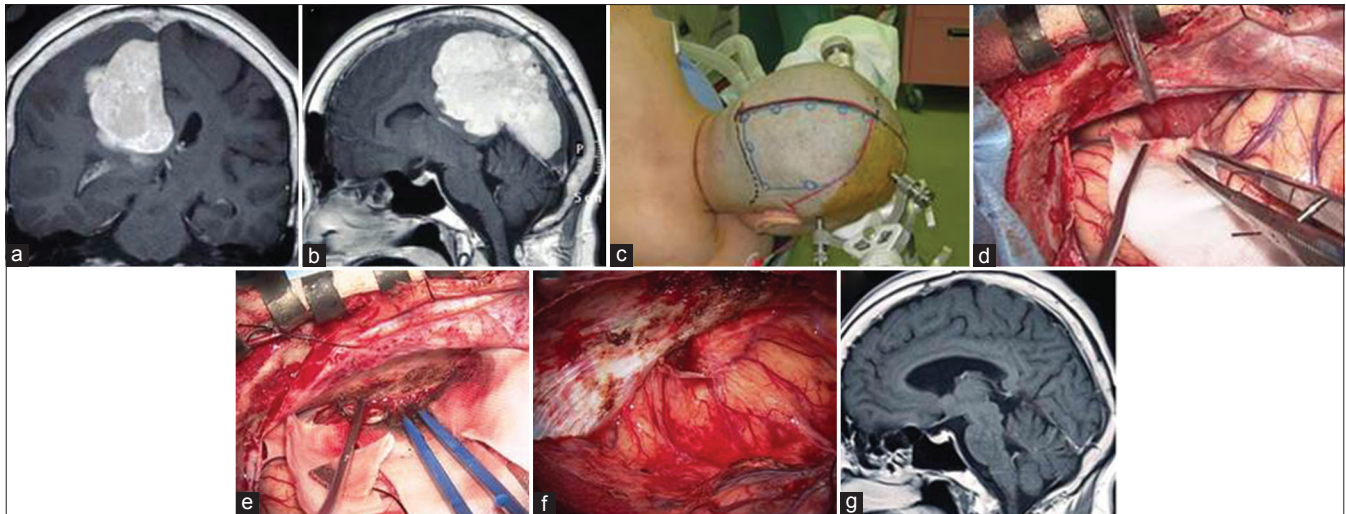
Case 1 – (a-f) Operative photographs showing surgical removal of the tumor through an occipital interhemispheric approach with gravity retraction of the occipital lobe in the lateral semiprone position (a and b). Devascularization and detachment from the falx were performed (c and d). Thereafter, internal decompression and dissection from the surrounding anatomical components were completed (e). Macroscopic complete removal was achieved (f). (g and h) Postoperative magnetic resonance images showing no remnant tumor or brain contusion
